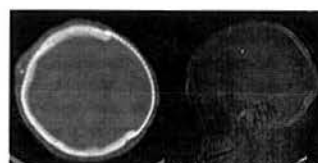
CT head imaging showing post surgical left fronto-temporo-parietal cranioplasty and extent of titanium mesh plating.
